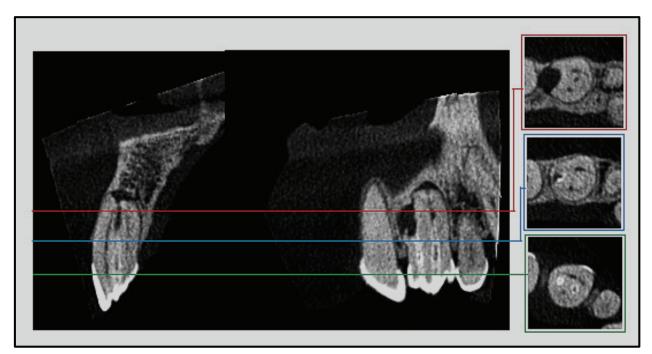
CBCT images confirming an invagination type III-A and III-B on the left maxillary lateral incisor (image adapted from Buchanan et al (2022)1).
